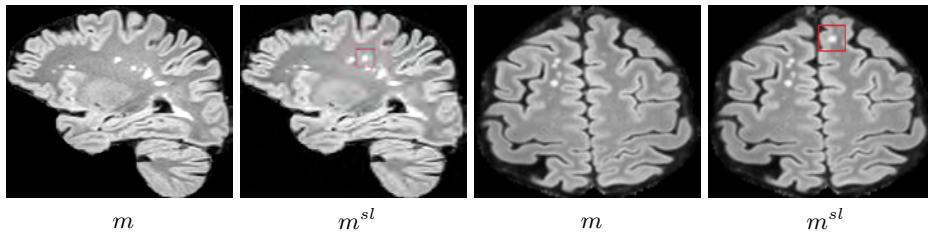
Additional examples of adding synthetic lesions into two different MRI scans.
